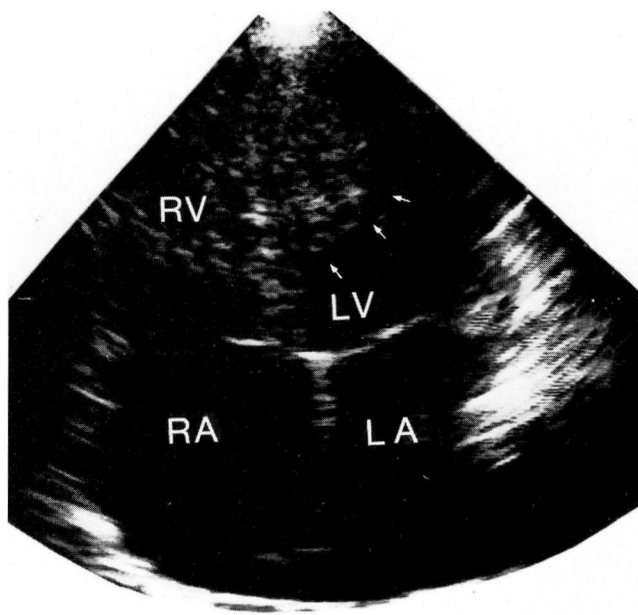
Case 2. Two-dimensional echocardiogram, four-chamber view, demonstrating a mass of echoes outlined by the arrows at the left ventricular apex. RA = right atrium; LA = left atrium; RV = right ventricle; LV = left ventricle.
